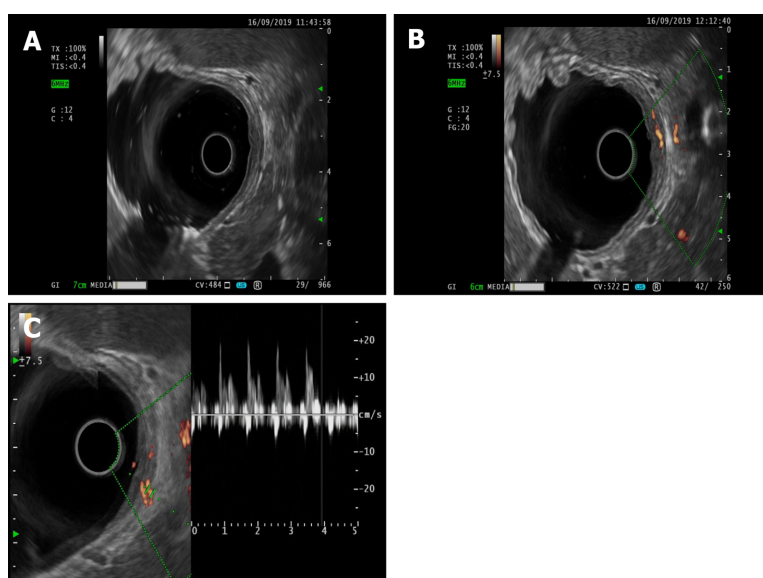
Endoscopic ultrasonography. A: Dieulafoy's lesion under endoscopic ultrasonography; B: Ultrasonic Doppler showing the blood flow signal of the myocombrane muscle and submucosa in the lesion area; C: Doppler spectrum representing the arterial blood flow spectrum.
